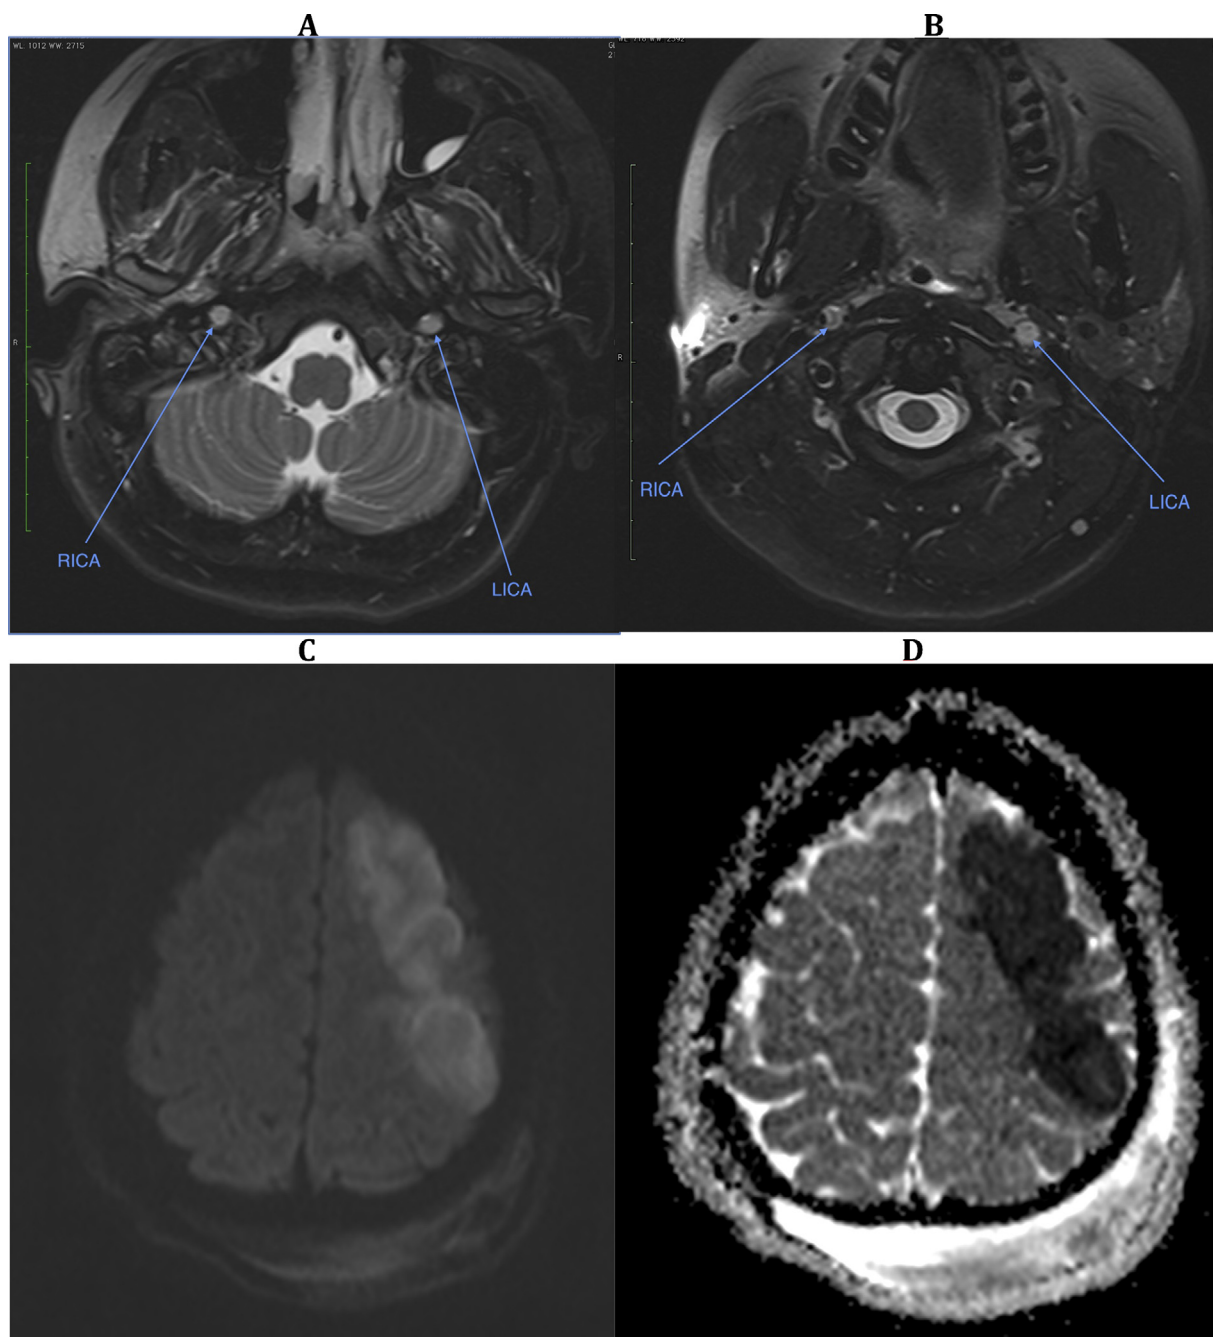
(A and B) MRI with technique of TSE FATSAT shows bilateral occlusion of carotid arteries. (C) T1 weighted axial MRI showing parenchymal changes corresponding with foci of infarct in subacute phase. (D) DWI ACE map is showing focal changes of the brain parenchyma in the left pole of the frontal lobe and in the posterior part of the left frontal lobe. RICA: right internal carotid artery, LICA: left internal carotid artery.
